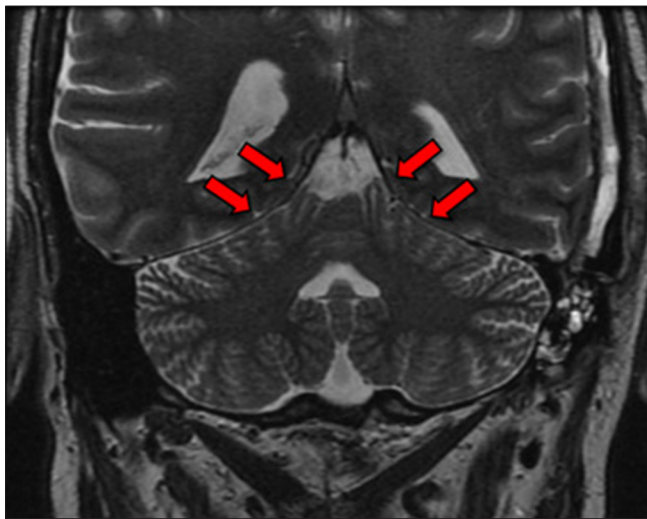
Coronal view of the T2-weighted sequence of the postoperative brain MRI of the patient from case number 2 is used to demonstrate that from lateral to medial, the tentorium acquires an increasingly superior course, so that it is difficult to reach medial structures through the subtemporal approach. The red arrows indicate the tentorium bilaterally.
